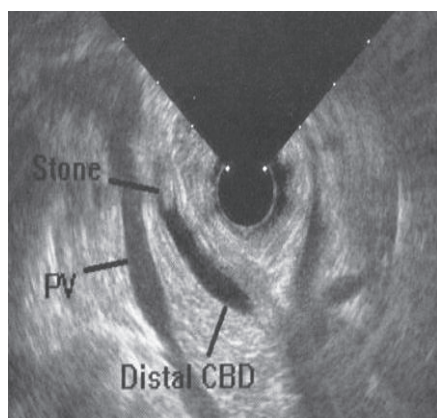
Endoscopic ultrasound showing a gallstone in the CBD.
